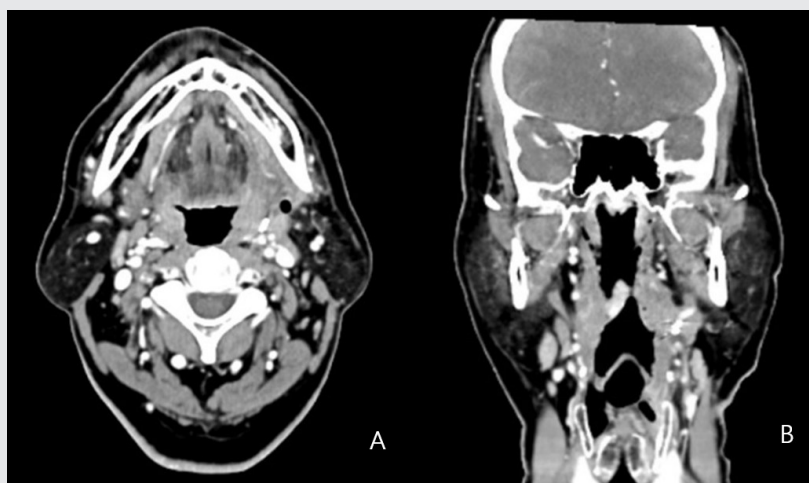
A. Axial view of CT, B. Coronal view of CT. The peritonsillar abscess and tonsillitis on both sides are resolved and the airway is well maintained.
